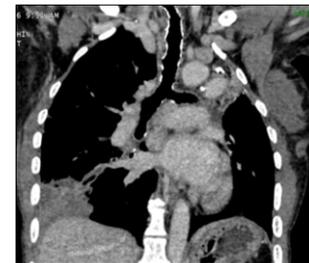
Coronal CT Chest reconstruction (delayed phase) showing wall irregularity and calcifications along lateral wall of distal trachea and right main bronchus.
